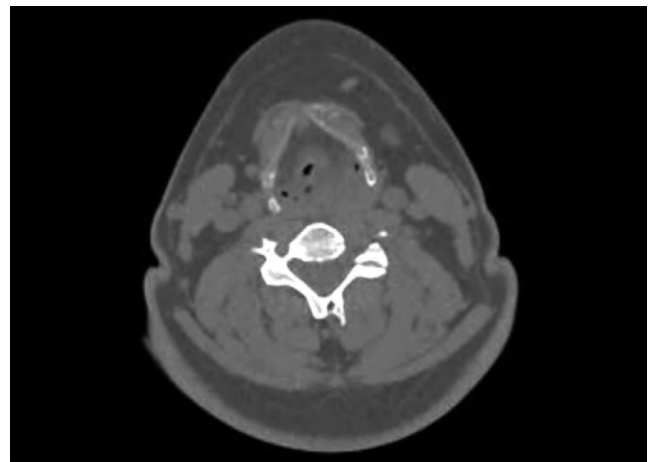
Computed tomography scan of the neck showing an oval mass located in the left pyriform sinus and extending into the ipsilateral paraglottic space
